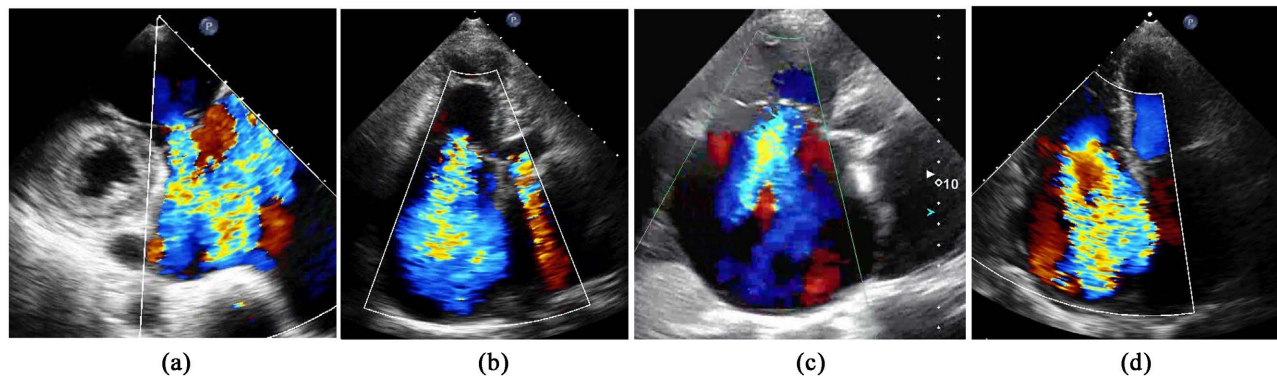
Preoperative echocardiography reveals severe TR in all cases ((a) case 1, (b) case 2, (c) case 3, and (d) case 4). TR, tricuspid regurgitation.
